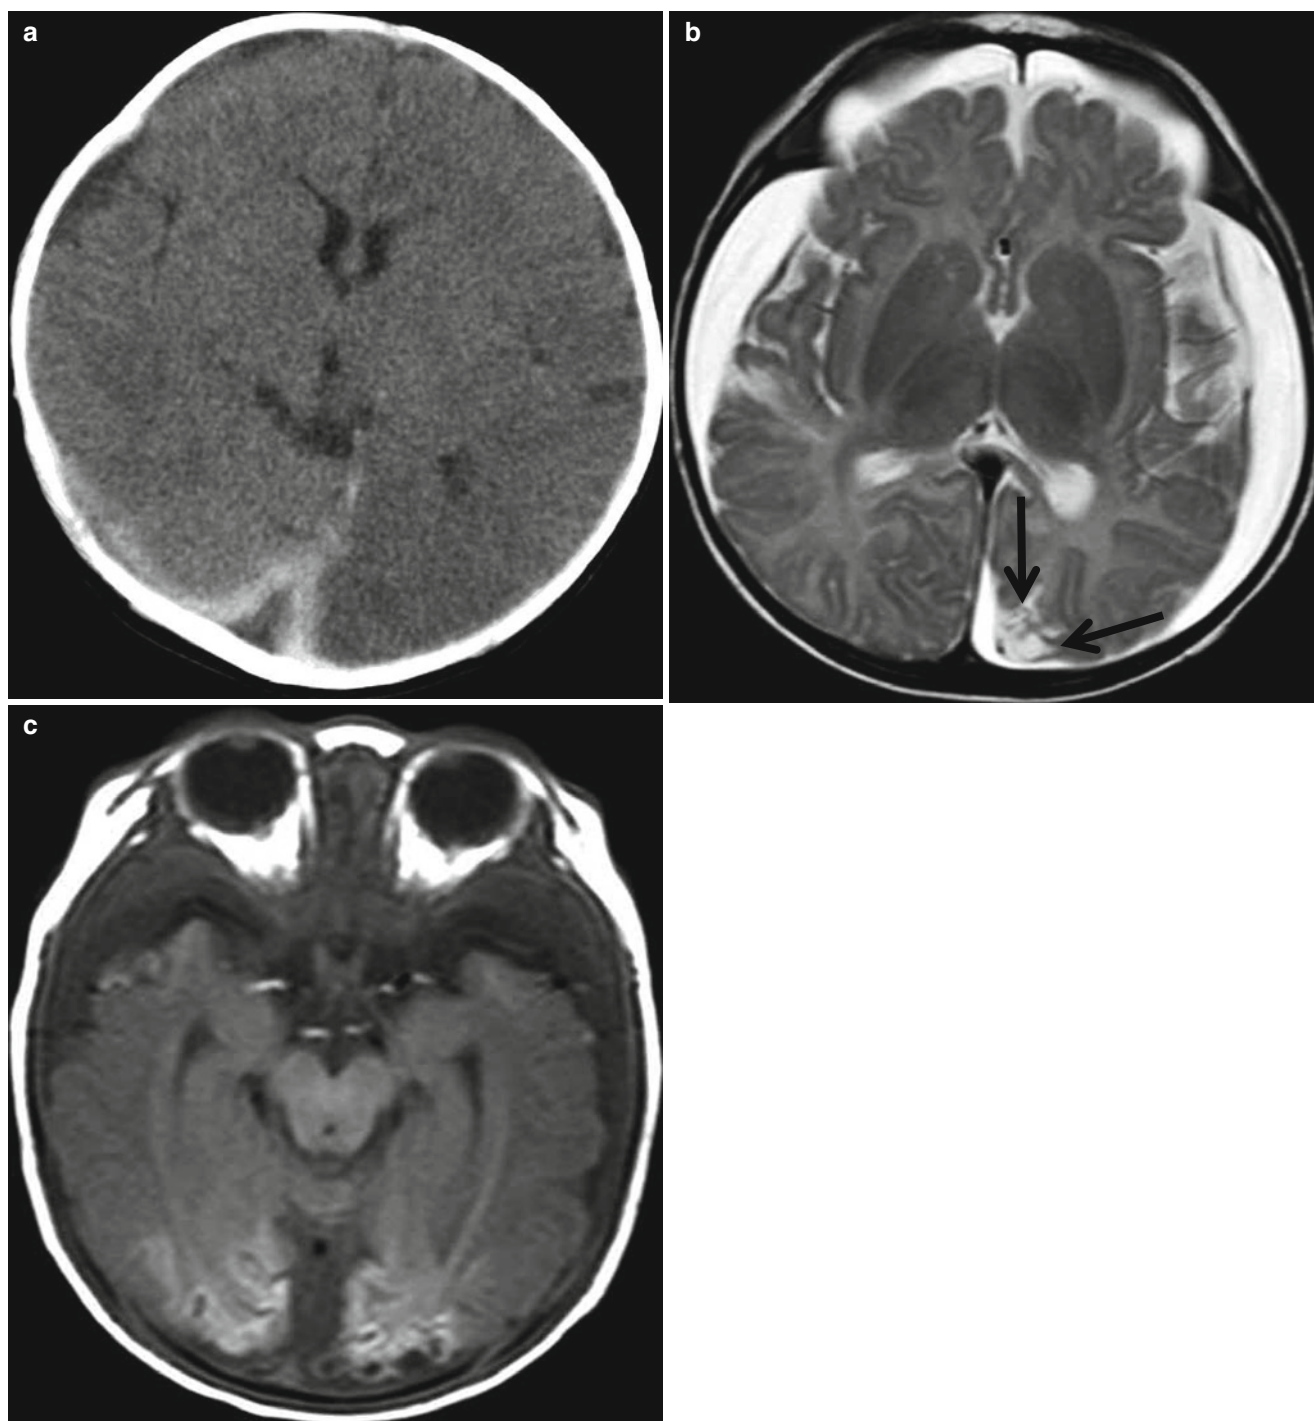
Child abuse in a 1-month-old infant. (a) CT scan shows hyperdense SDH and subtle low attenuation of the left occipital lobe. (b) T2-weighted image obtained 1 month later reveals focal encephalomalacia
